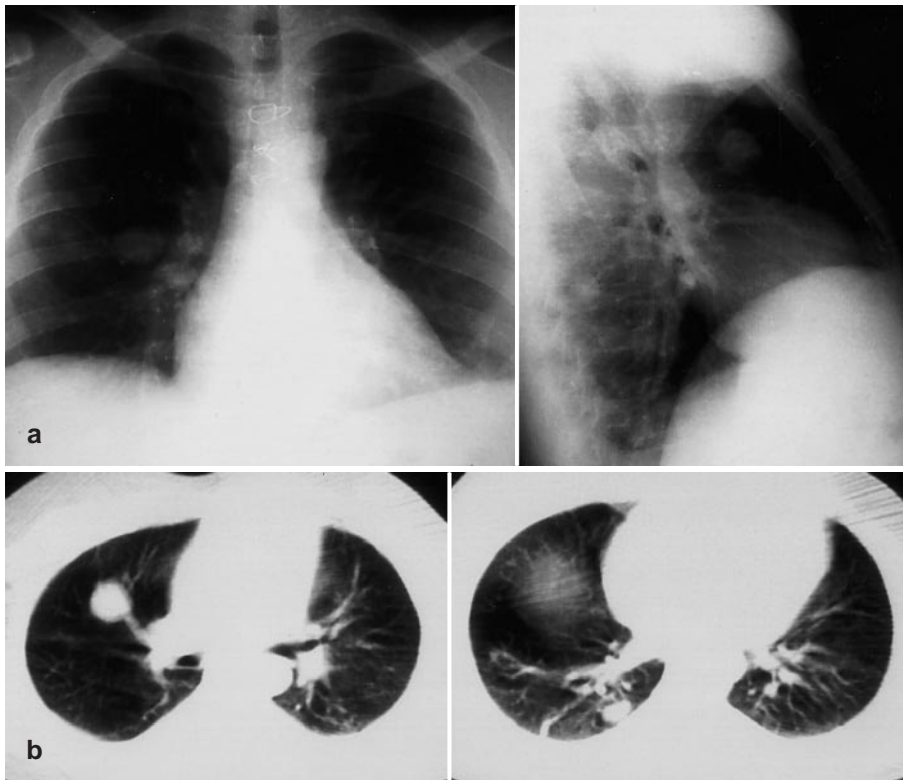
Case 1. a Chest radiographs and b CT scan in May 1993, 2 years after removal of the metastases, show that new nodules have appeared and the previous one has increased in size
